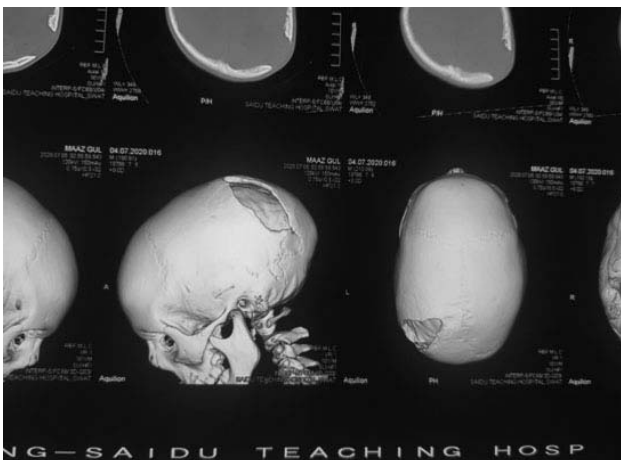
CT scans anatomical imaging of fractures in skull
